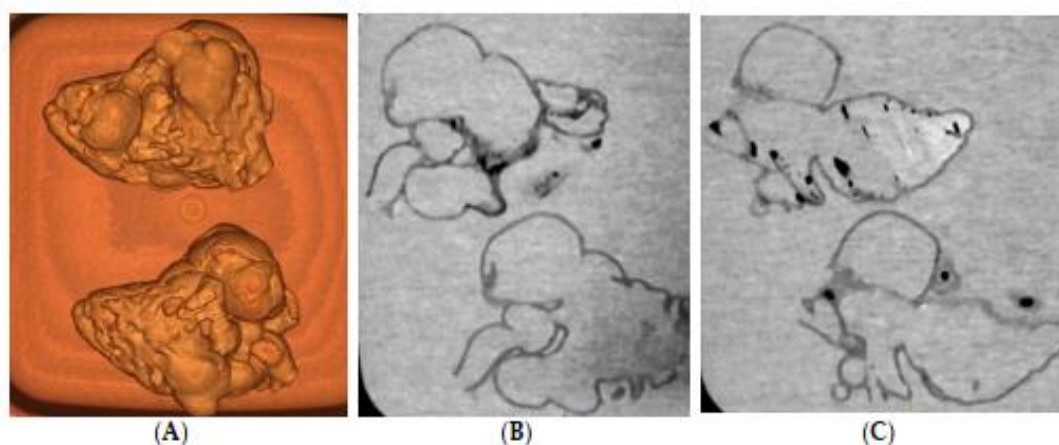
CT scan of 3D printed heart models created using different printing materials. (A) 3D volume rendering showing the 3D printed models without contrast medium (top: Tango Plus material, bottom: TPU material). (B,C) Coronal multiplanar reformatted contrast-enhanced CT images showing 3D printed models with Tango Plus (left) and TPU (right) materials. Air bubbles are noticed in the model with TPU material. TPU—thermoplastic polyurethane. Reprinted with permission under the open access from Lau et al. [45].
